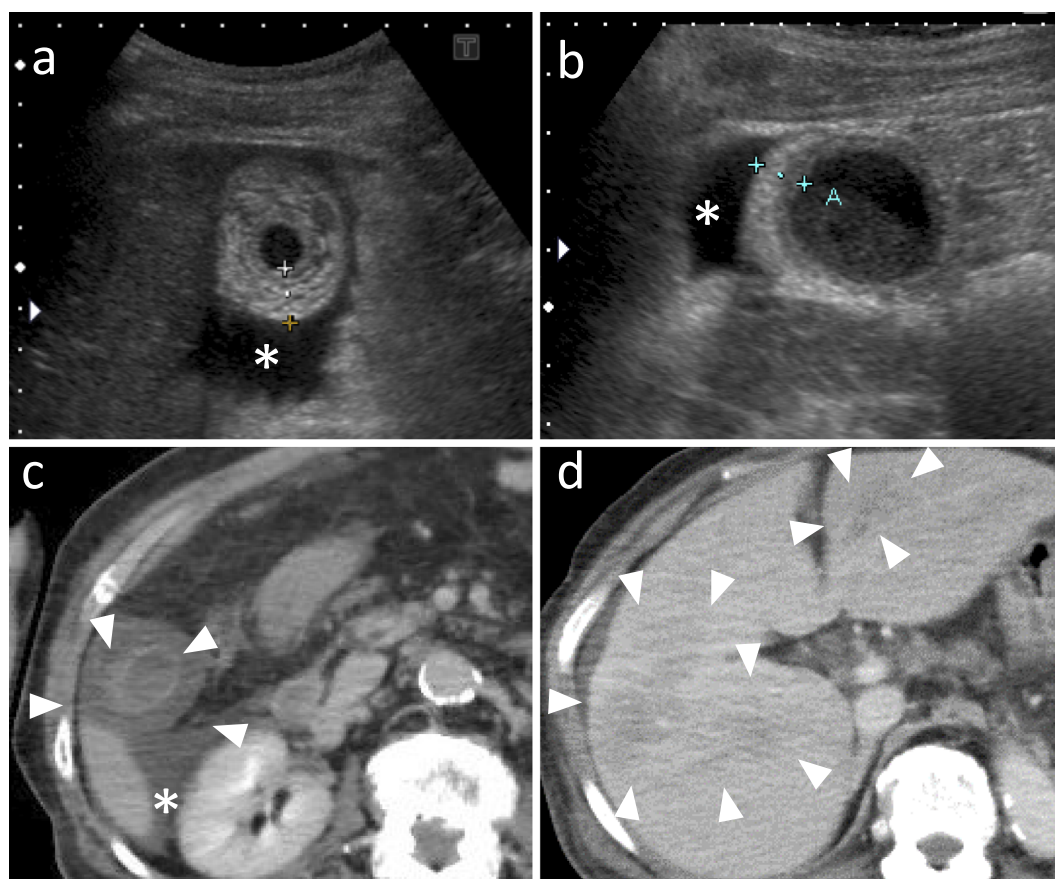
Imaging studies of the hepatobiliary system. (a) Ultrasonogram revealing an extremely thickened gallbladder wall and fluid collection (*) on admission. (b) The thickness of the gallbladder wall regressed 5 days after admission. (c) A computed tomography scan showing an extremely thickened gallbladder wall (arrowheads) and fluid collection (*) on admission. (d) A hypovascular area of the liver is shown (arrowheads) 9 days after admission.
